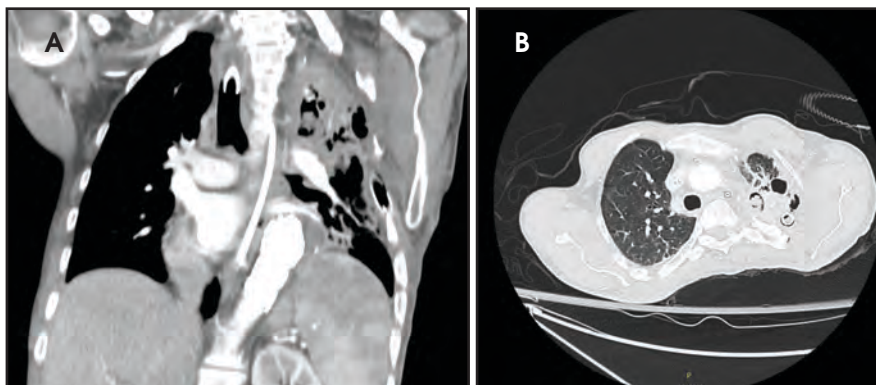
Diagnostic computed tomography images with representative coronal (A) and axial (B) sections showing an aspergilloma in the left upper lobe.
